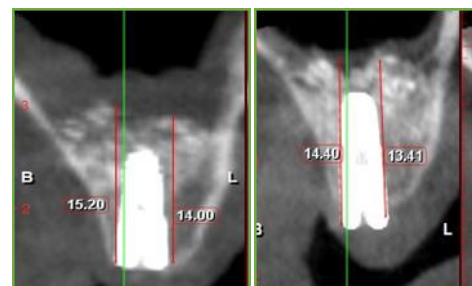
Bone height gain: (A) cross sectional immediate post-operative CBCT; (B) 6 months post-operative CBCT (The authors' elaboration)
